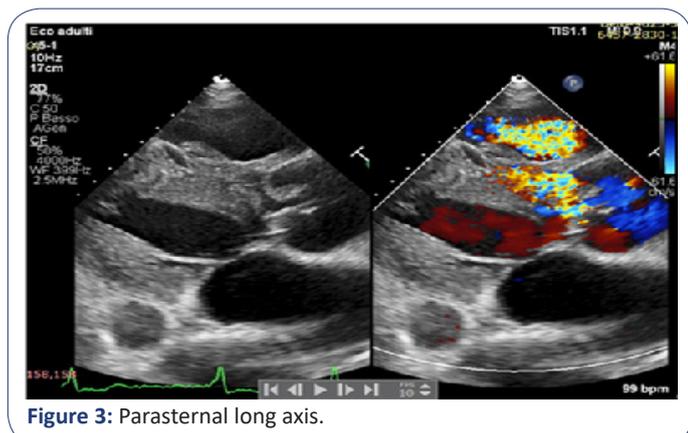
Parasternal long axis.
